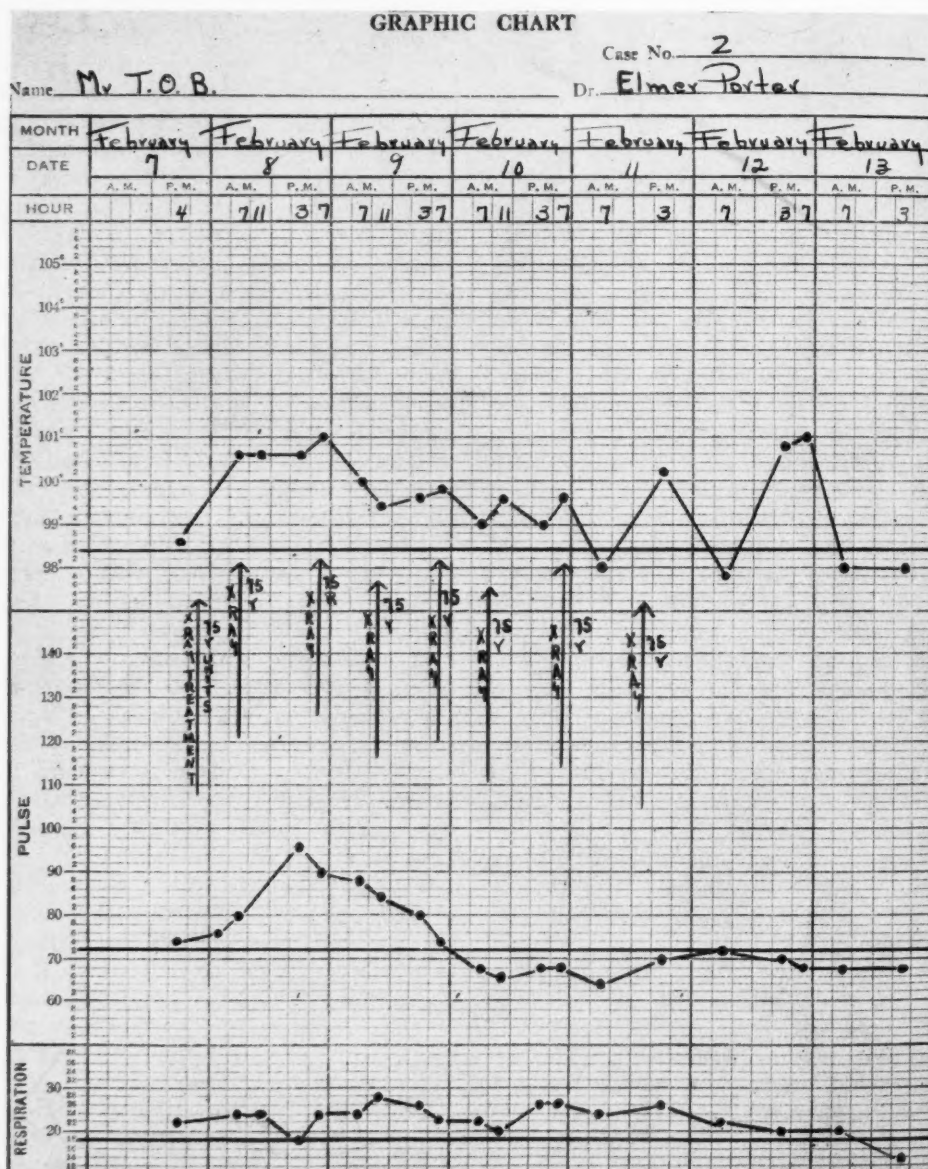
Case 2. Diagnosis: peritonitis, perforated appendix. X-ray technic: kv. 110; ma. 5; distance 50 cm.; filter 3 mm. Al; r units, 75 per treatment, total 600; port, lower abdomen anteriorly; result, excellent.
